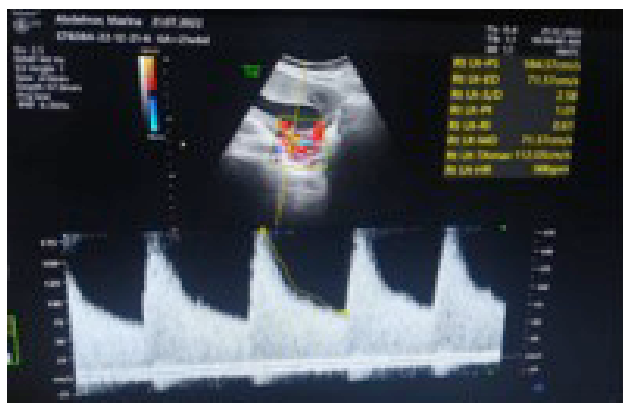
Uterine artery Doppler in the first trimester of pregnancy.
